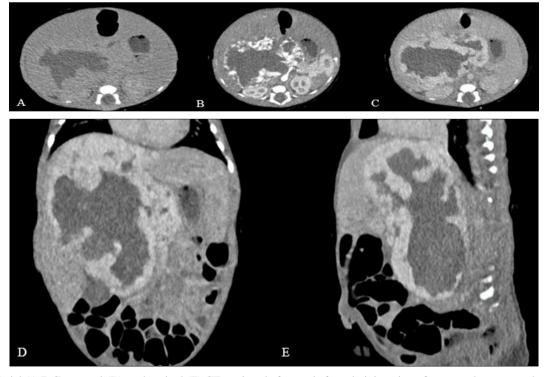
Axial (A,B,C) coronal (D), and sagittal (E) CT sections before and after administration of contrast demonstrated a massive intraperitoneal tumor mass which arose from segments IV, V, VI, VII, and VIII of the liver. The mass was oval in shape with a lobulated border and heterogeneously enhanced on contrast administration. It featured a central zone of hypodensity consistent with extensive necrosis with serpentine vessels in its periphery.
